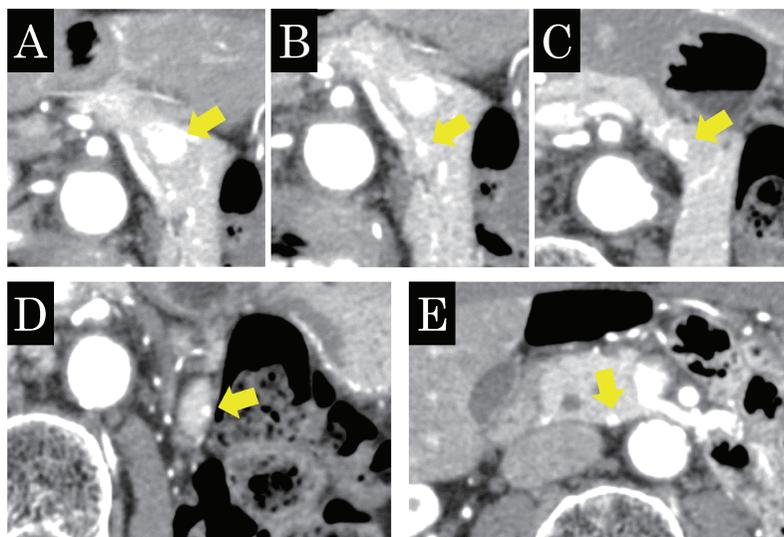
Pancreatic phase of multiphase contrast-enhanced computed tomography
